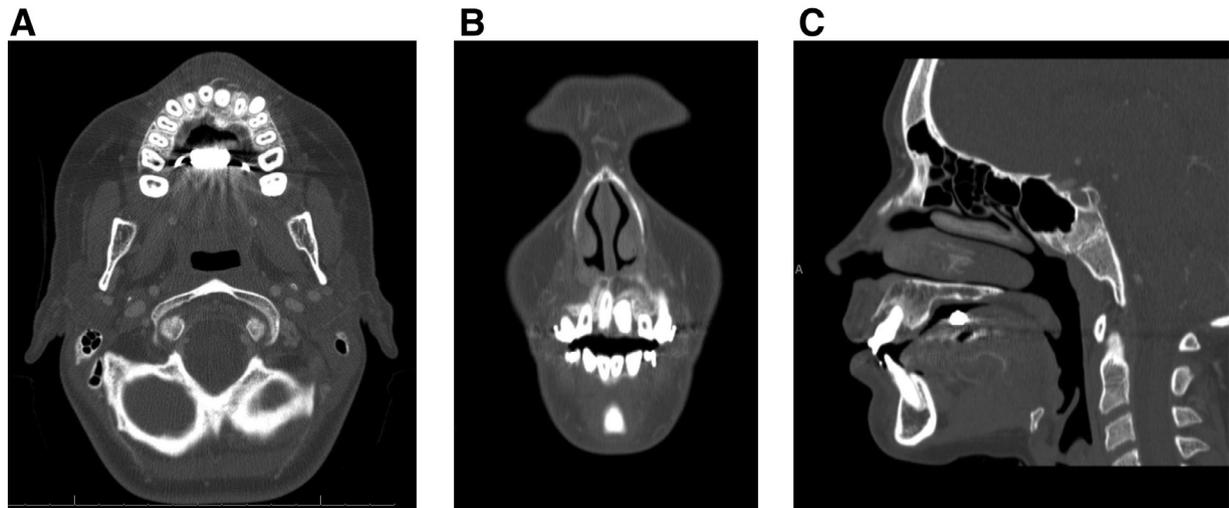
Facial computed tomography (CT) scan obtained after patient presented again to clinic. (A) Axial view. (B) Coronal view. (C) Sagittal view. The irregularly shaped hypodensity surrounding the resorbed root of tooth #9 has enlarged. There is persistent surrounding sclerosis along with increased buccal and palatal expansion.
